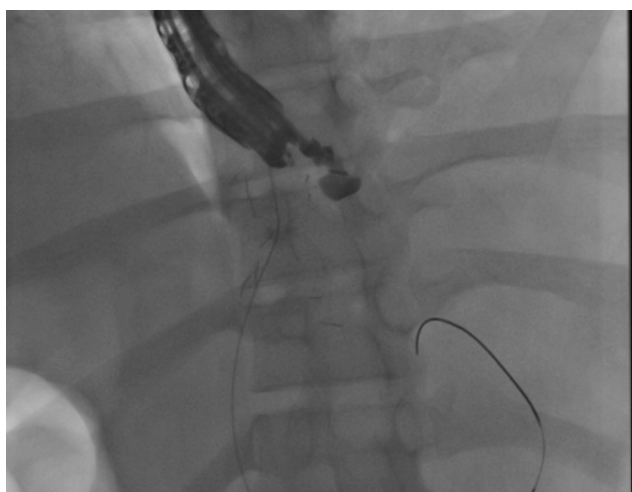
Endoscopic ultrasound-guided drainage of walled-off necrosis with lumen apposing metal stent.
